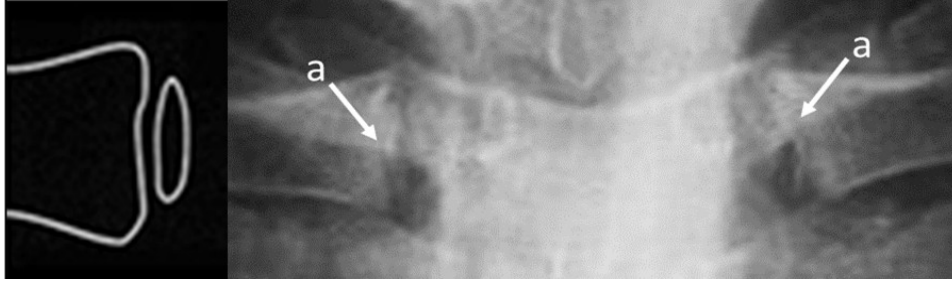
Radiograph of a 19-year-old patient showing stage 2 ossification: the estimated age = 18 years. a — gap between epiphyses and diaphysis.
